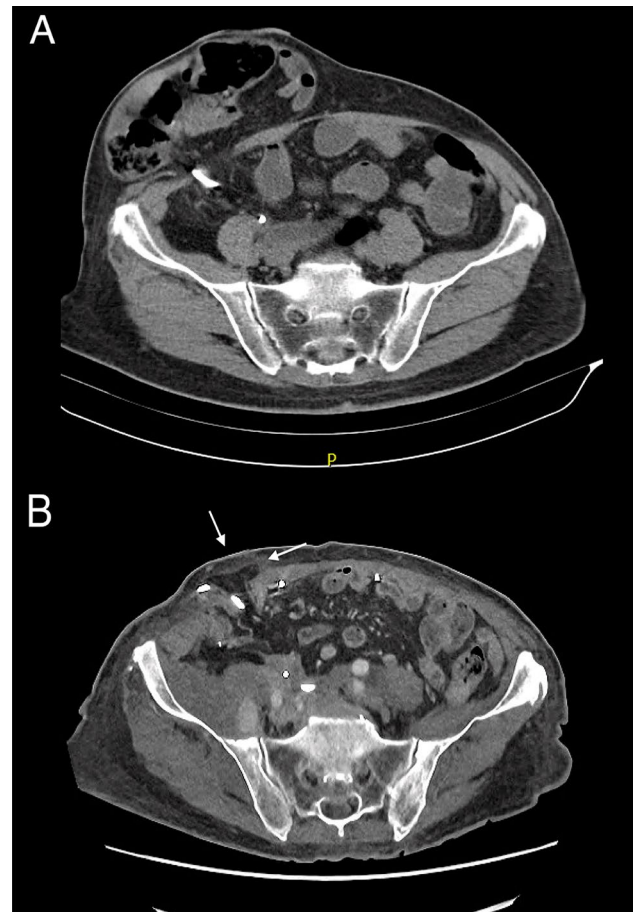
Pre- (A) and post- (B) operative computed tomography a male patient suffering from a radiologically-identified Moreno-Matias grade Ia recurrence (white arrows on B) 24 months after a modified Sandwich procedure. Ureter drains were present in the ileal conduit on both exams
